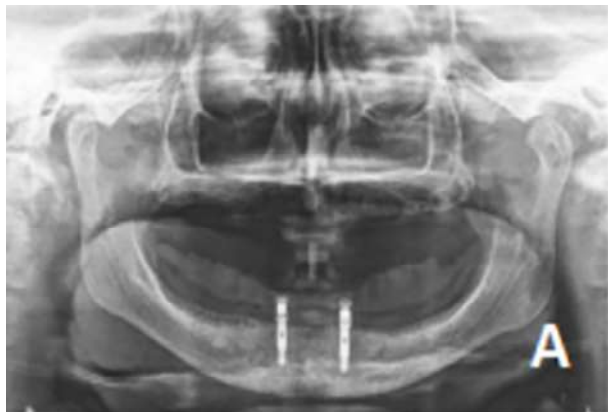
Radiographic evaluation after five years, showing little mandibular bone loss; and the aesthetic result of rehabilitation.
